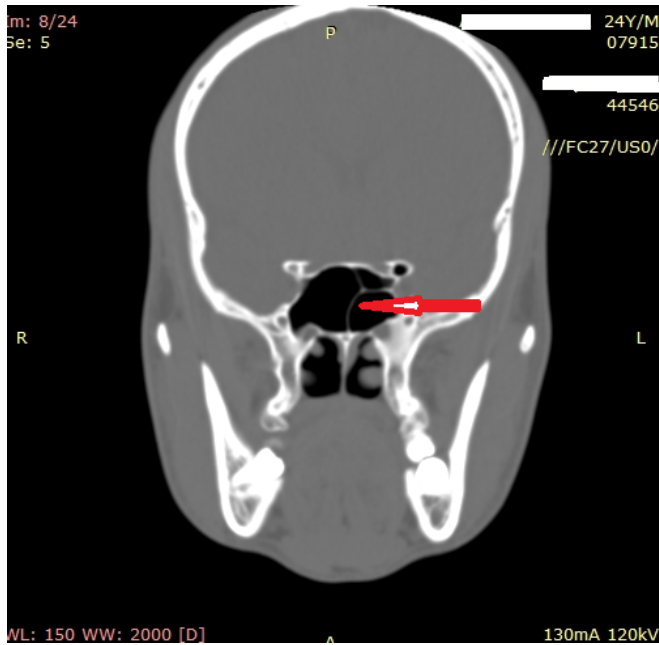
CT scan of PNS - Coronal section showing Sphenoid sinus septation.
